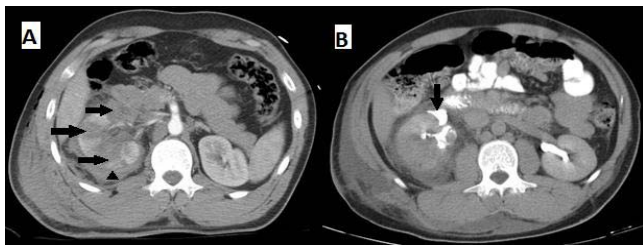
Case 1. A) CT scan accomplished after the trauma. Contrast-enhanced nephrographic-phase helical CT scan shows several deep lacerations of the interpolar region of the right kidney (arrows) and perinephric hematoma (arrowhead). B) CT scan performed three days after trauma. Contrast-enhanced excretory-phase CT scan shows extravasation of contrast in the kidney Upper Right (arrow).
